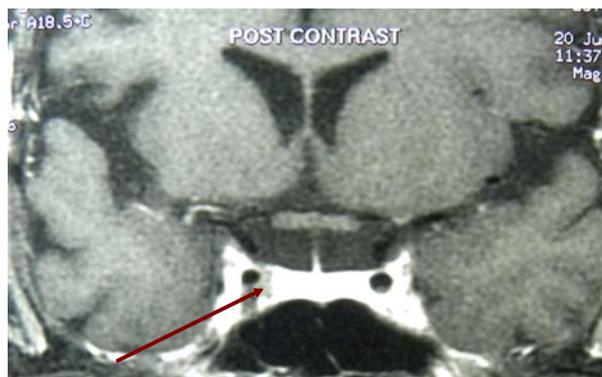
MRI pituitary – arrow showing the micro adenoma.
